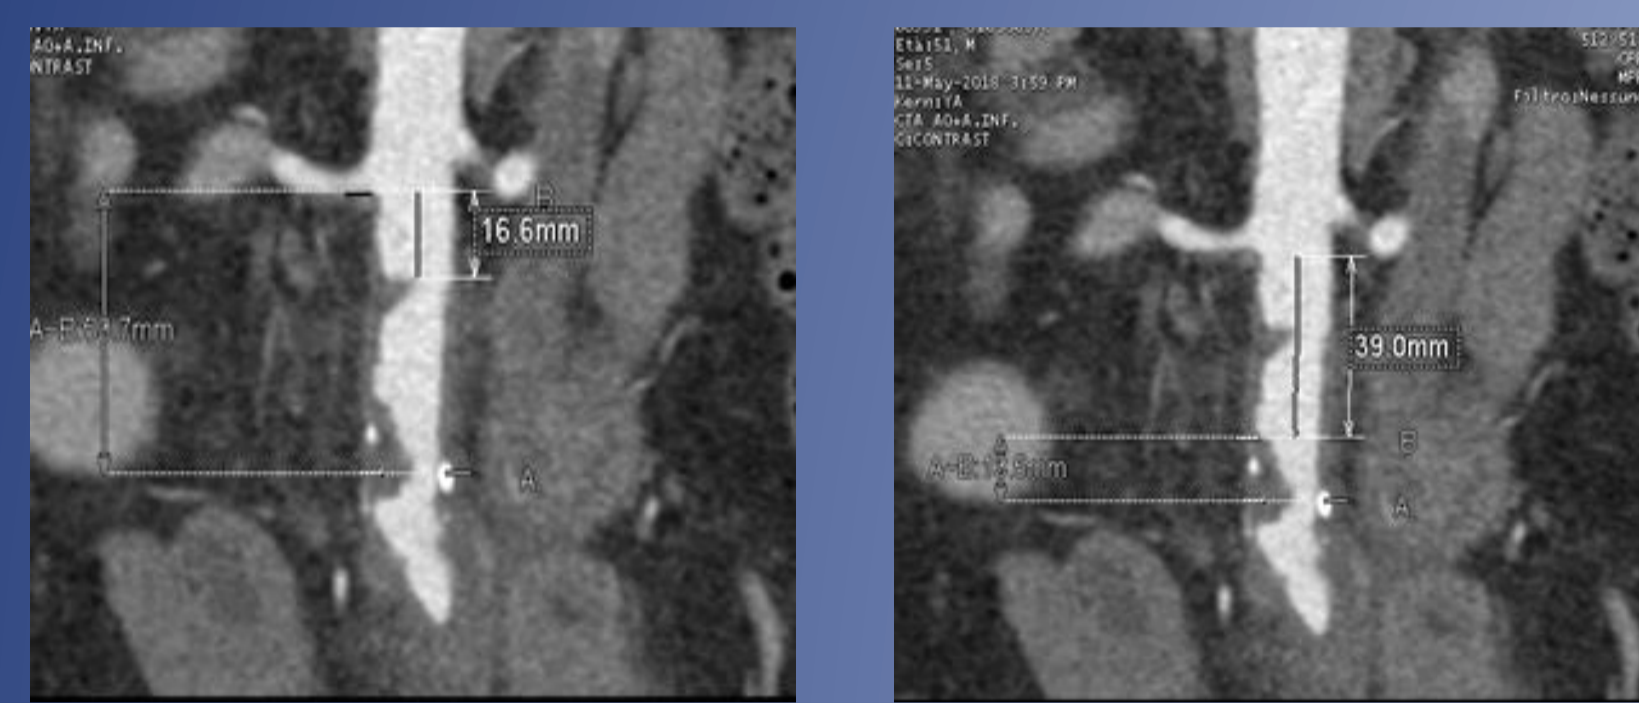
Preoperative CTA. On the left, coronal images showing presence of aortic thrombus at the site of previous clamp placement causing narrowing of the lumen. On the right, CPR reconstructions showing the occlusion of the right aorto-femoral bypass (WHITE ARROW) and right external iliac stent (BLUE ARROW).
